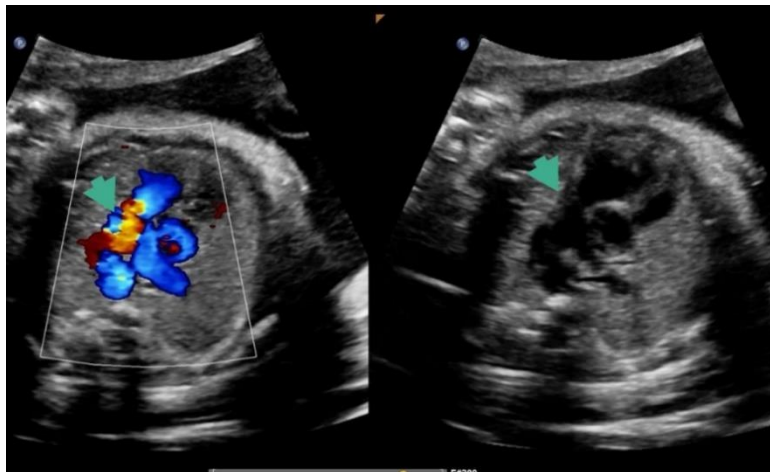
Demonstrating right ventricular outflow view with color Doppler showing acceleration in pulmonary valve with mild stenosis.
